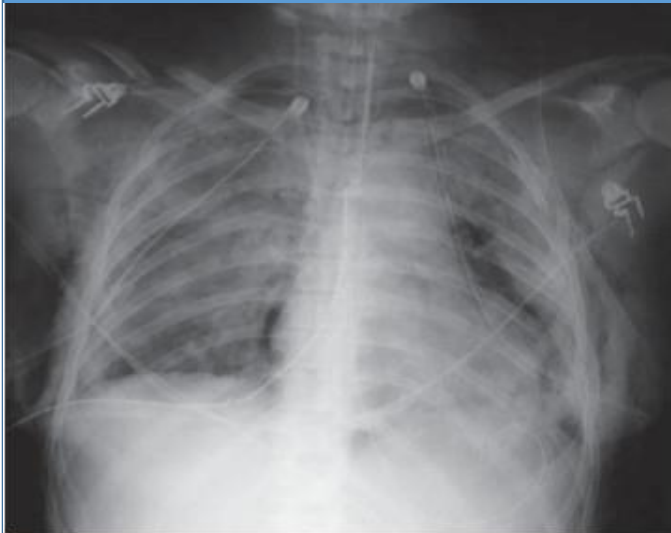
Chest X-ray in acute respiratory distress syndrome (ARDS). Note bilateral lung infiltrates, pneumomediastinum, pneumothoraces with bilateral chest drains, surgical emphysema, and fractures of the ribs, right clavicle and left scapula.
